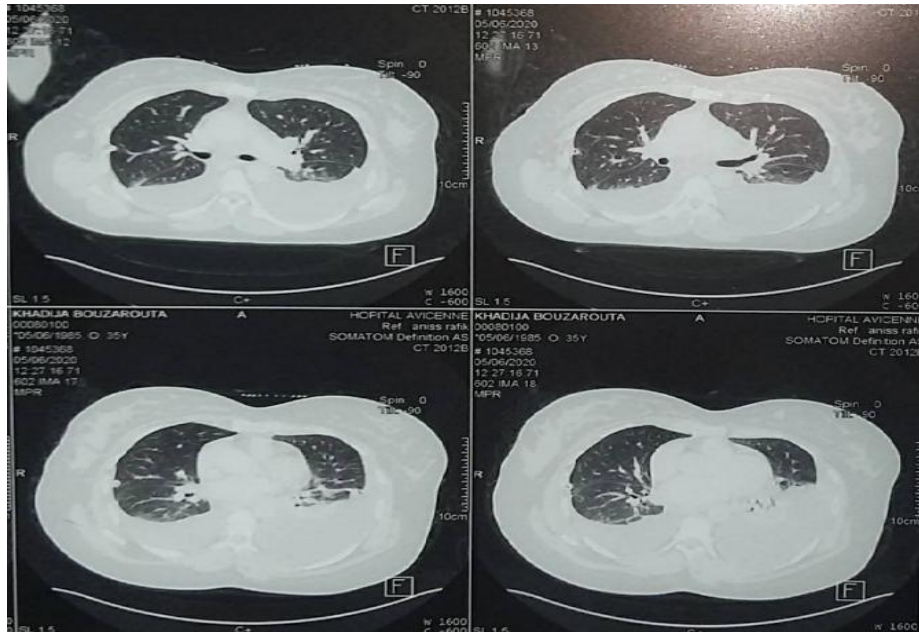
Cervico-thoracic CT showing a compressive goiter at the expense of the left lobe, pushing back the trachea and vascular structures.
